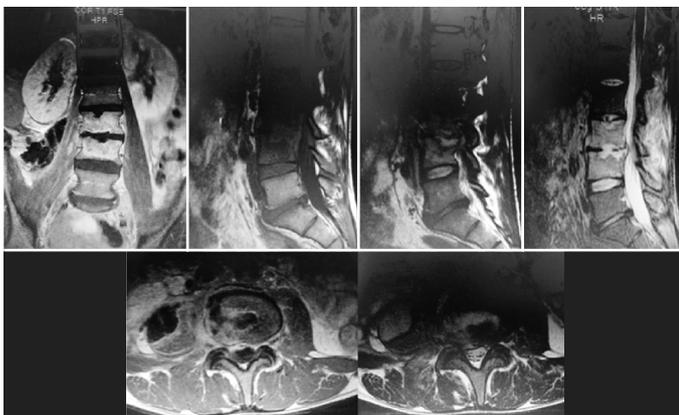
Case 34. MRI coronal, sagittal T1, T2 and T2 with contrast and Axial T1 with contrast and T2 without contrast. Defined as L3-L4, A, C1, O2, +. (Region L3-L4, Anterior Location, the PSEA moves the content, Association with disc and bone infection, Lateral Perivertebral/Psoas).
